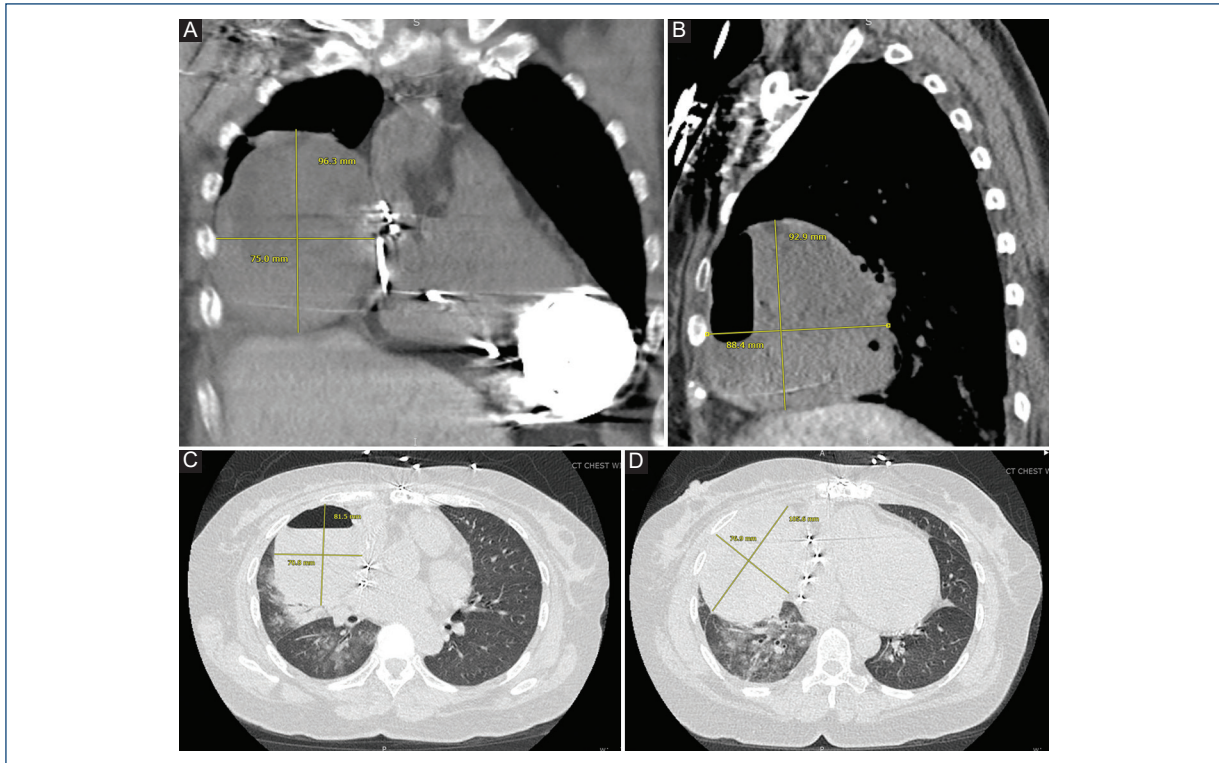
Chest computed tomography evidencing a large right lung bulla with internal hemorrhage (panels A-D). The bulla measured 105.6 mm in its widest diameter, and there was a fluid-air level in its more cephalic portion.
